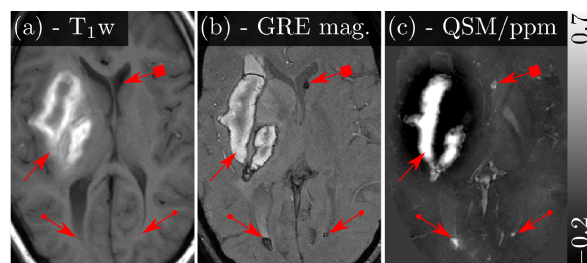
Patient B with hemorrhage into basal ganglia. Non-enhanced T1-weighted image (a), GRE magnitude image (b), susceptibility map (c).
